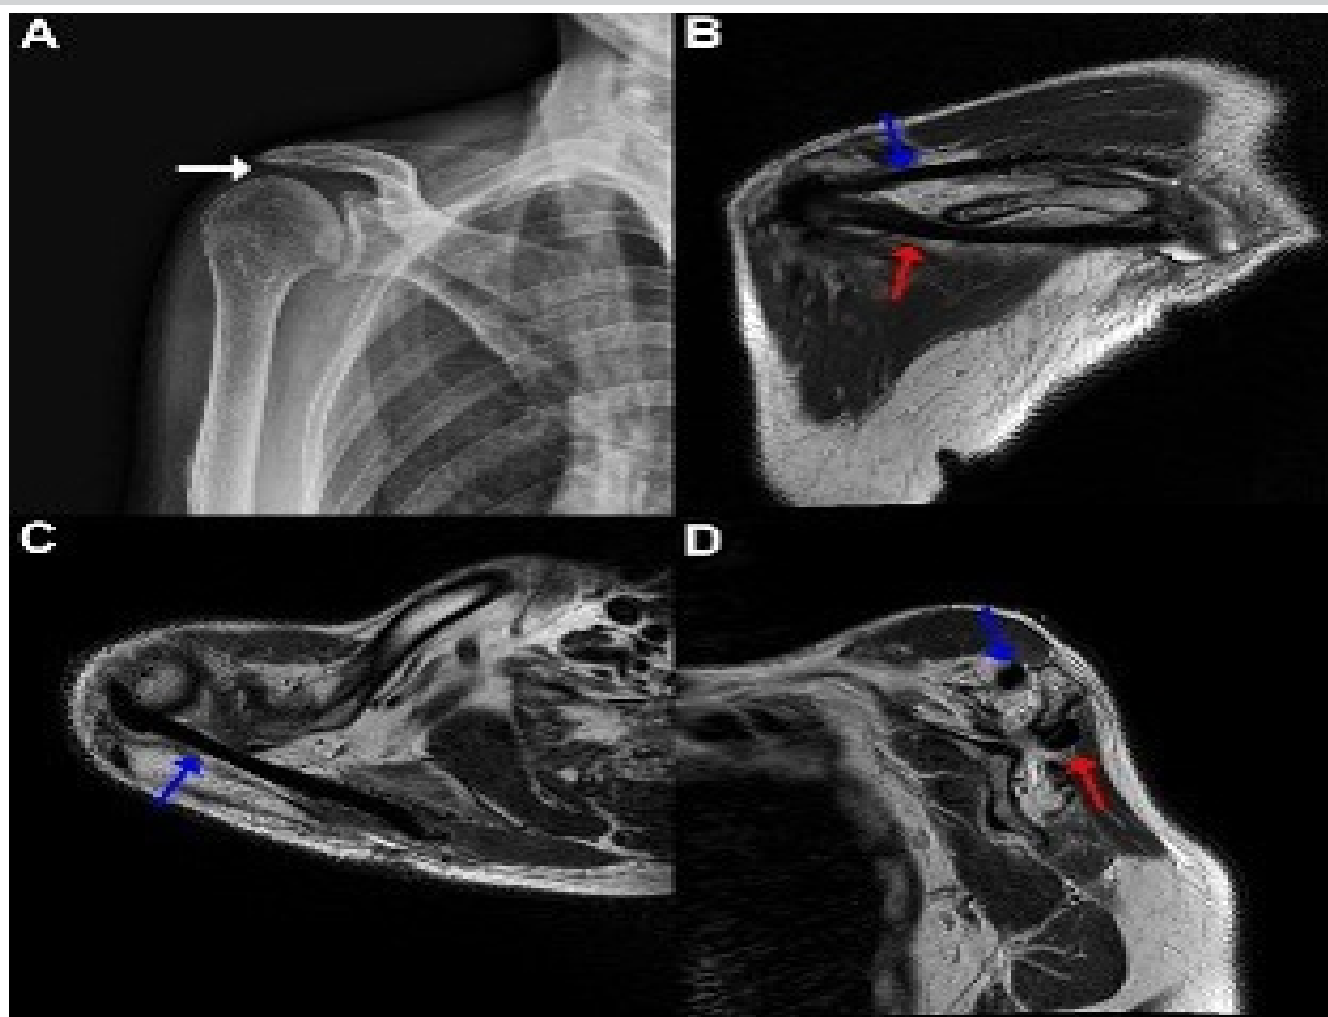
Post-radiograph and magnetic resonance imaging (MRI). (A) Post-operative radiograph of the right shoulder shows an increased in acromiohumeral distance (white arrow) and no further progression of arthritis of glenohumeral joint in true anterior posterior view. The post-operative MRI shows intact integrity of transferred tendon attached to both middle trapezius (blue arrow) and lower trapezius (red arrow) in (B) oblique coronal, (C) oblique axial, and (D) sagittal view.
